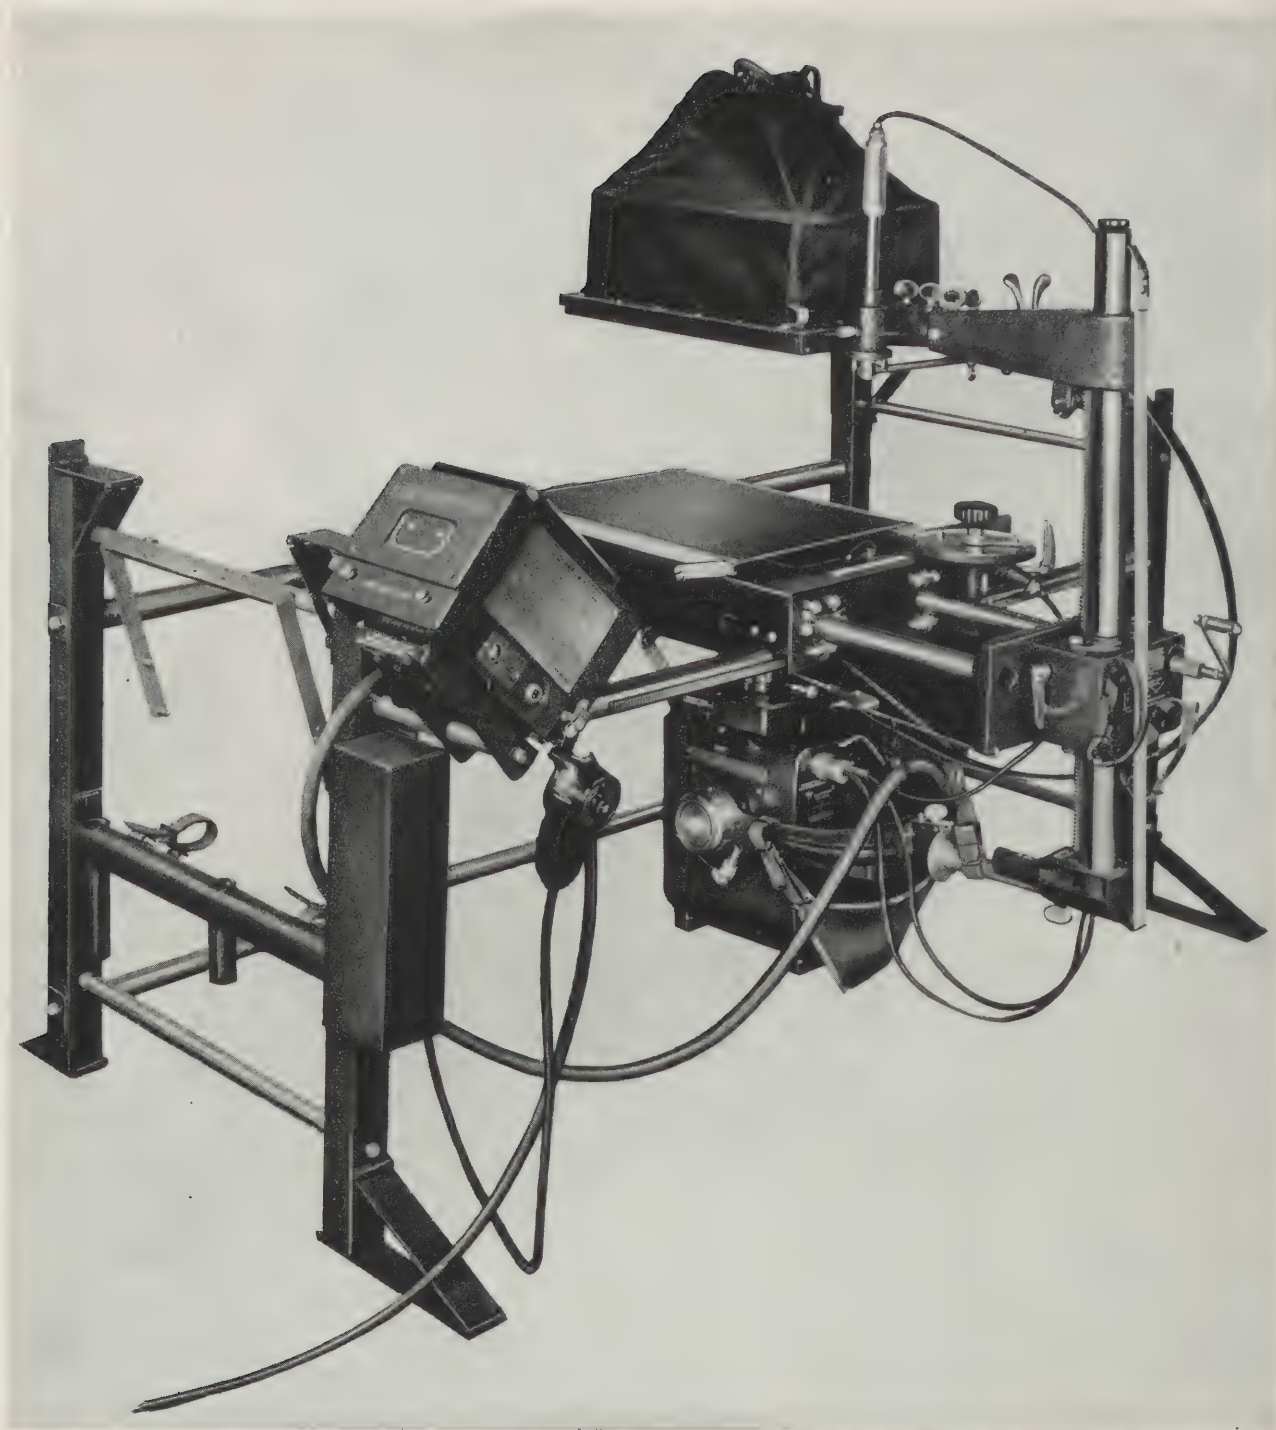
Item 96215, combination X-ray machine and table assembled for foreign body localization and roentgenoscopy.
